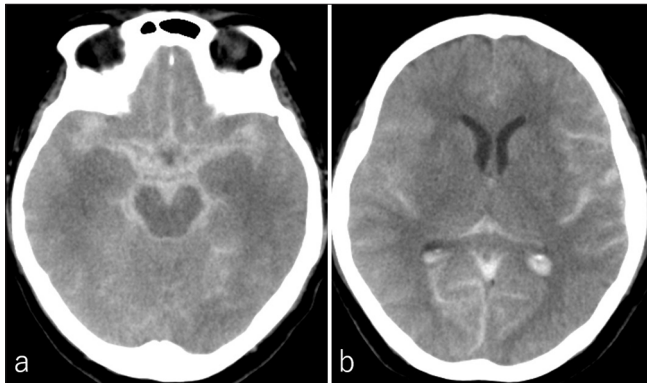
(a and b) Cranial computed tomography performed on postoperative day 1 showing diffuse subarachnoid hemorrhage without ventricular dilation.
